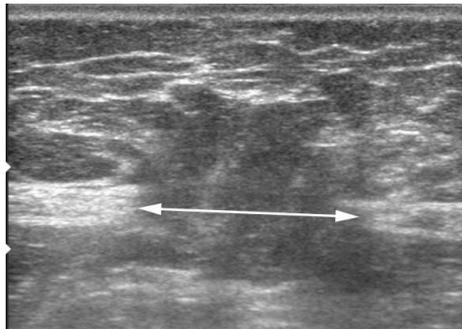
Preoperative transverse sonogram of an incisional hernia after reconstruction of an aortic-iliac occlusion that occurred 5 years previously shows a defect of the linea alba (double arrow) with a protrusion of the hernial sac consisting of preperitoneal fat.
